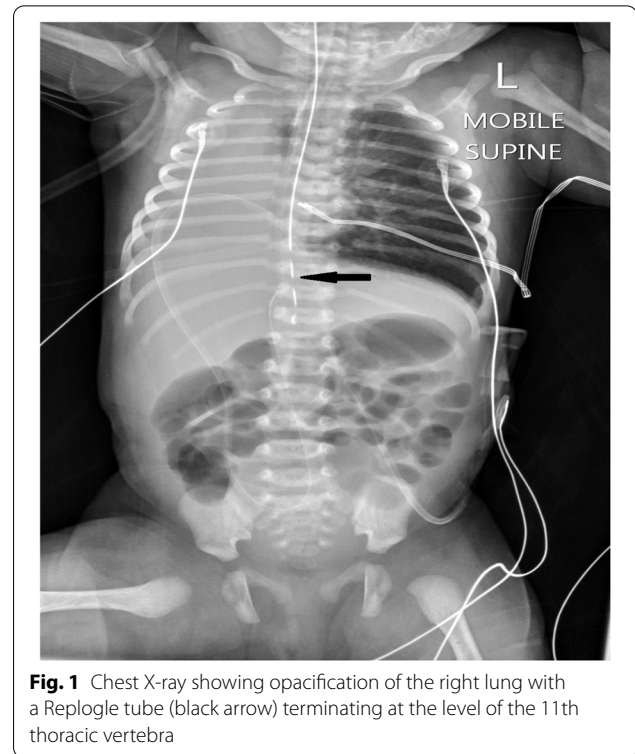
Chest X-ray showing opacification of the right lung with a Replogle tube (black arrow) terminating at the level of the 11th thoracic vertebra
